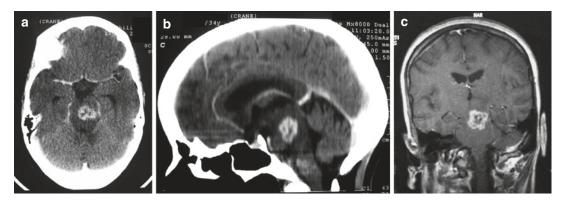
Brainstem (pontomesencephalic) tuberculoma (case $n^{\circ}3$). Axial (a) and sagittal reconstructions (b) CT scan after contrast administration and coronal cranial T1-weighted MRI after gadolinium injection (c)
